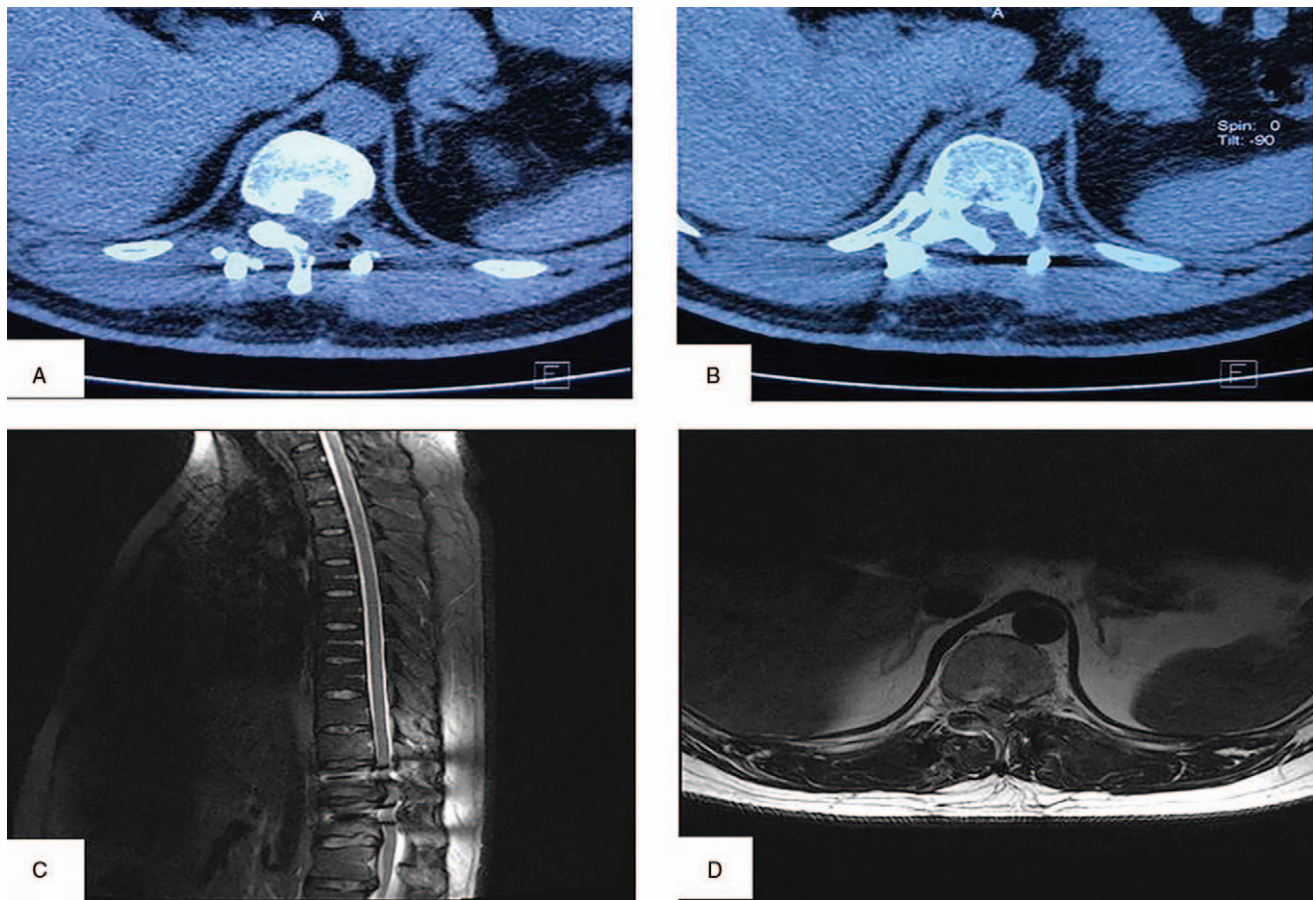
Postoperative CT images and MRI images: (A and B) Postoperative CT images showed adequate semi-lamina decompression at T11/T12 levels. (C and D) Postoperative MRI images showed adequate semi-lamina decompression at T11/T12 levels.
